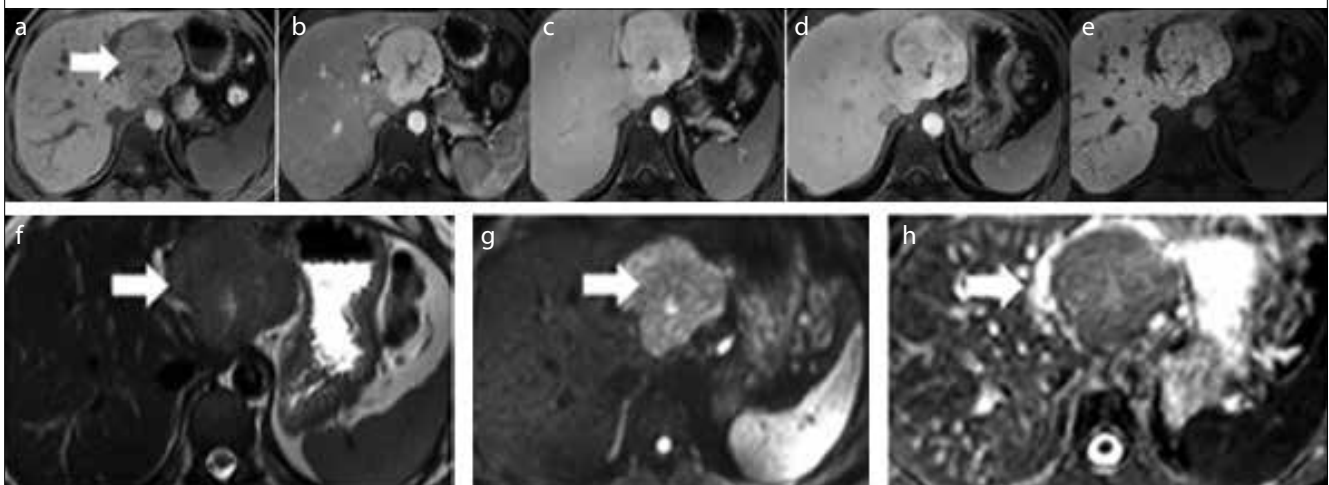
a-h. FNH in the left lobe of the liver of a 30-year-old male patient: (a) non-contrast; (b) arterial T1-weighted image showing marked contrast enhancement; (c) portal venous; (d) hepatic venous; (e) slight hyperintensity in T1-weighted imaging liver-specific phase at 20 minutes after injection of contrast agent; (f) typical central scar on T2-weighted axial image; (g) shine-through pattern on DWI, $b=600$ sn/mm²; (h) slight restricted diffusion on the ADC image
